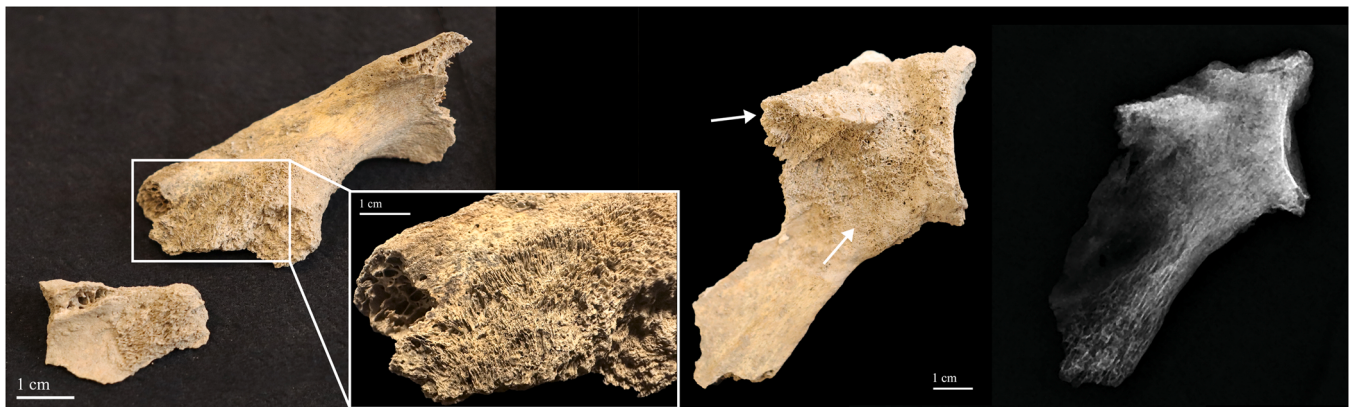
Left (on the left) and right (center and x-rays on the right – posterior views) scapulae of individual US 7154 (conventional radiographs parameters: 70 kV, 2 mAs, 0.03 s). Note the thick and spiculated new bone deposits on the cortical surface (white arrows).
